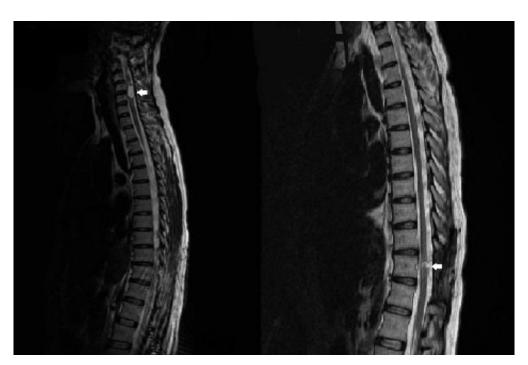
Spinal MRI, sagittal FLAIR sequence showing cervical ependymoma and thoracic schwannoma (*arrows*).
